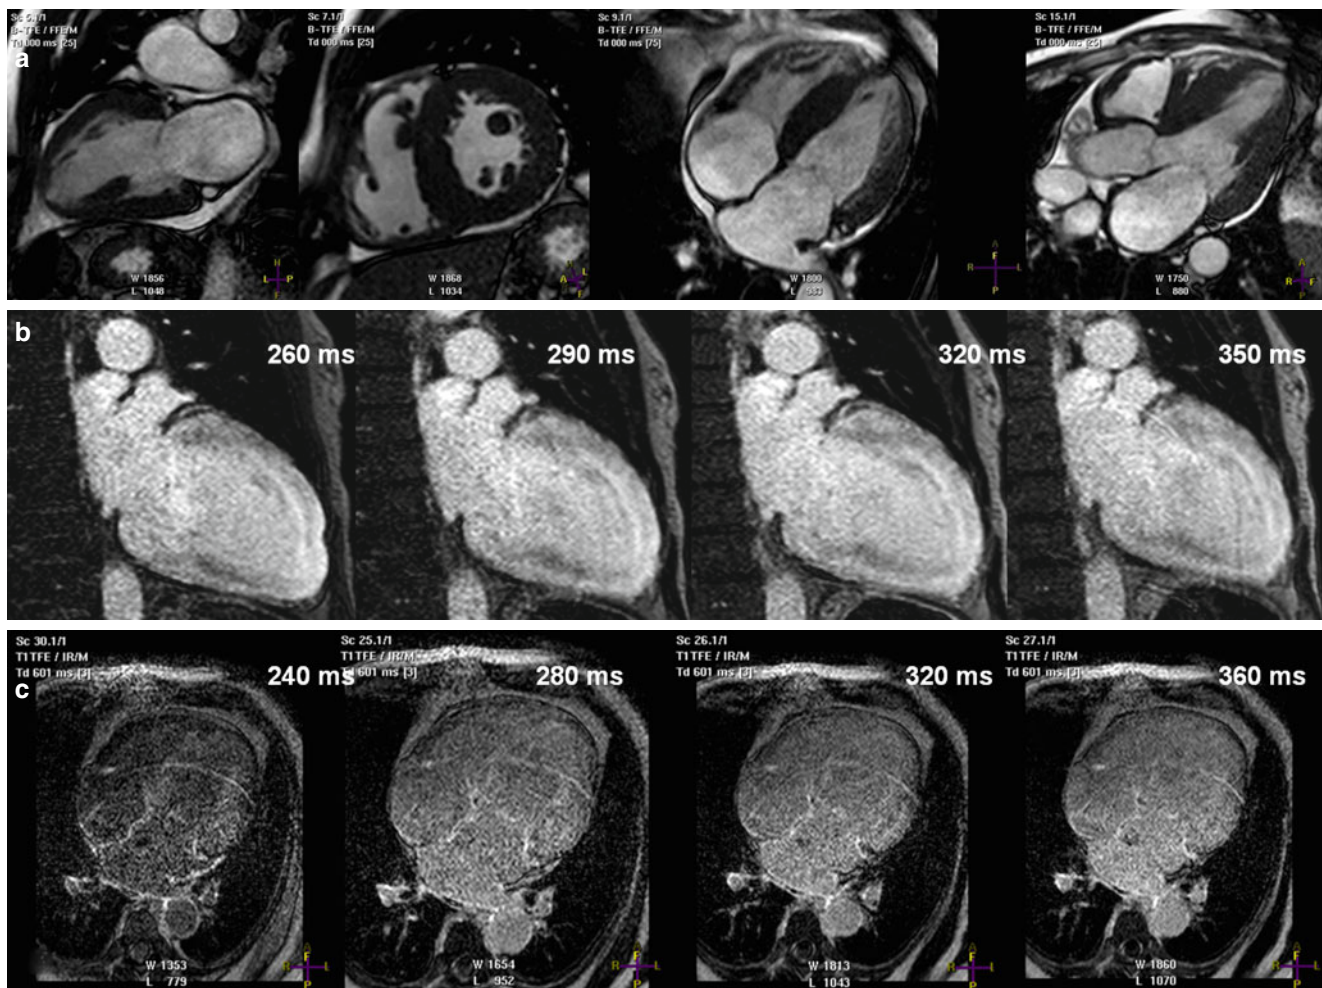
Images from a 68-year-old man who presented with malaise, biventricular failure, and a history of multiple myeloma. The *top row* (a) shows still frames acquired by using steady-state free precession in various orientations. They show left ventricular hypertrophy and, possibly, mild right ventricular hypertrophy. The *middle row* (b) shows images acquired by using delayed-enhancement magnetic resonance imaging (DE-MRI) in the two-chamber orientation. In these
